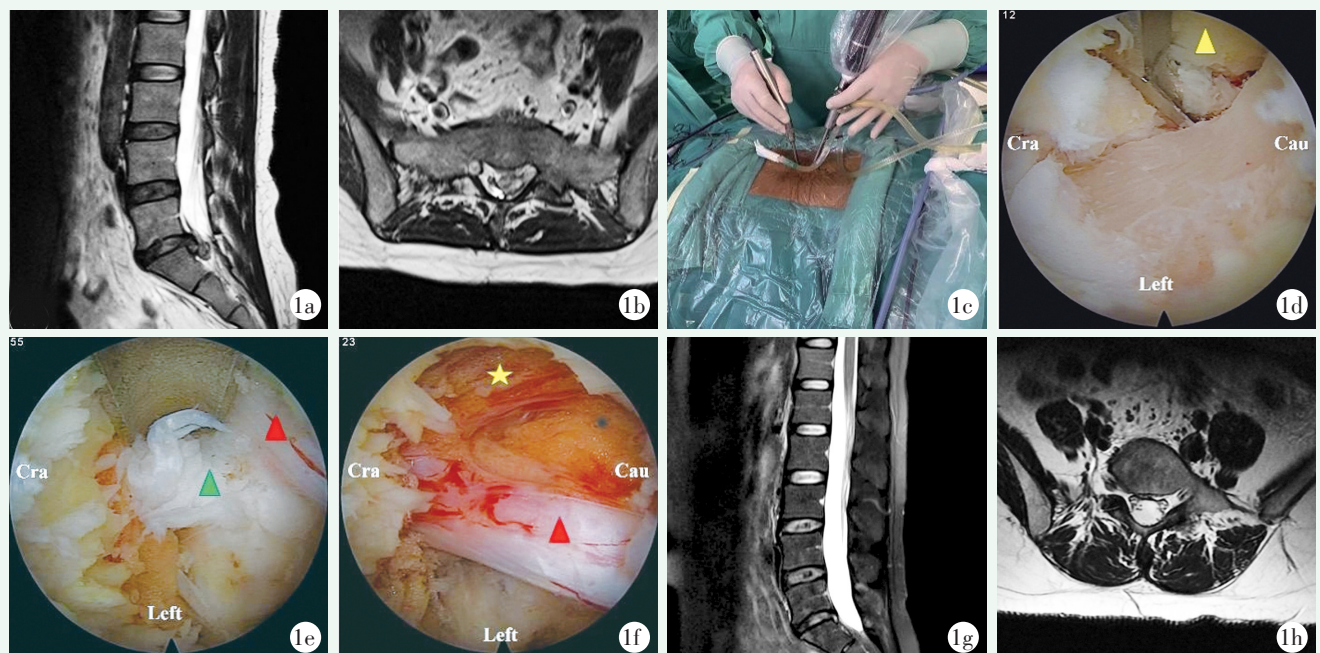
患者女性, 36 岁, L₅S₁ LDH (左侧)。1a: 术前腰椎矢状位 MRI 示 L₅S₁ 椎间盘左侧突出, 并挤压左侧 S₁ 神经根及硬膜囊; 1b: 术前腰椎轴位 MRI 示 L₅S₁ 椎间盘左侧突出, 并挤压左侧 S₁ 神经根及硬膜囊; 1c: UBED 术中工作通道建立; 1d: 椎板咬骨钳扩大同侧椎板间窗; 1e: 术中内镜下左侧 S₁ 神经根受压状态, 绿色箭头显示突出髓核组织, 红色箭头指示左侧 S₁ 神经根; 1f: 髓核摘除后神经根松弛, 表面血运恢复, 红色箭头为左侧 S₁ 神经根, 黄色星号为硬膜囊; 1g, 1h: 术后腰椎 MRI 示硬膜囊形态基本恢复, S₁ 神经根无受压。
